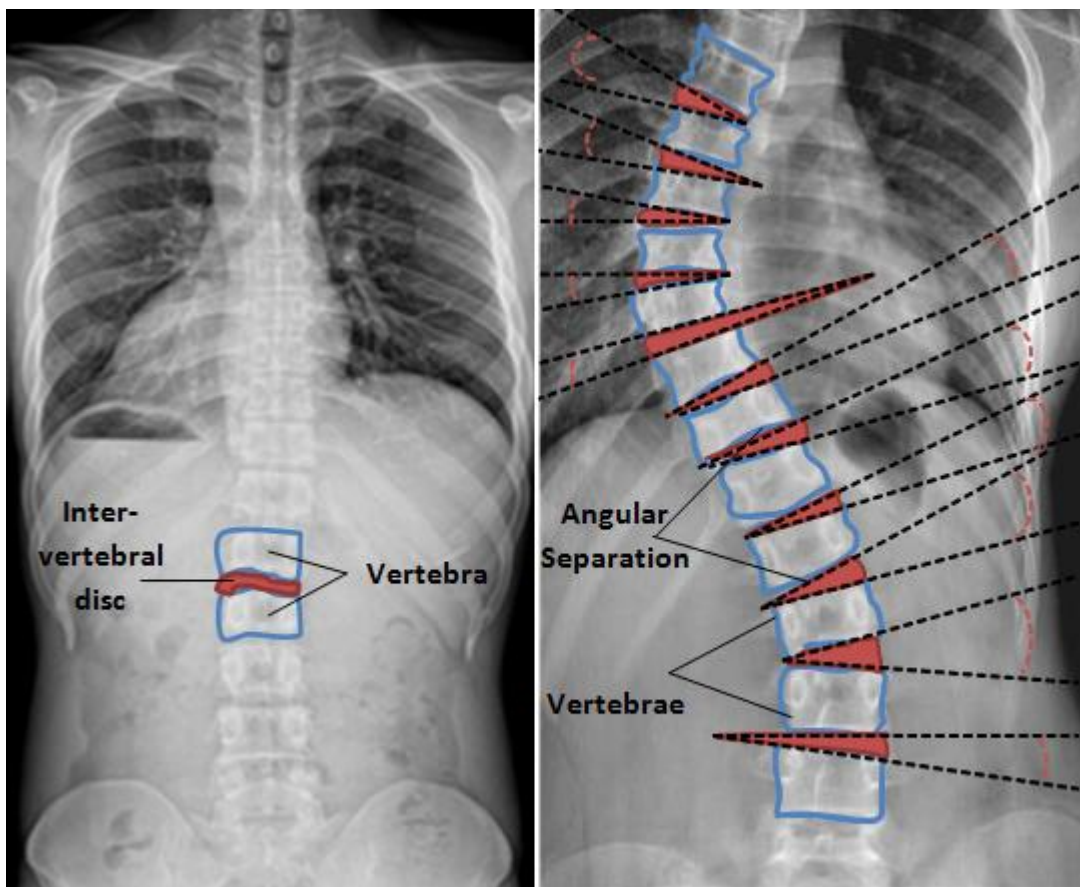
X-ray images of normal and scoliosis spines
